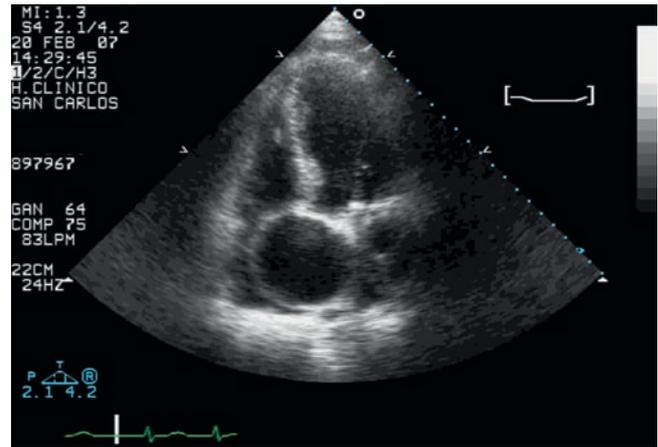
Transthoracic echocardiography (TTE). Four-chamber view. A large ascending aorta aneurysm can be clearly seen. Right atrium compression is evident
